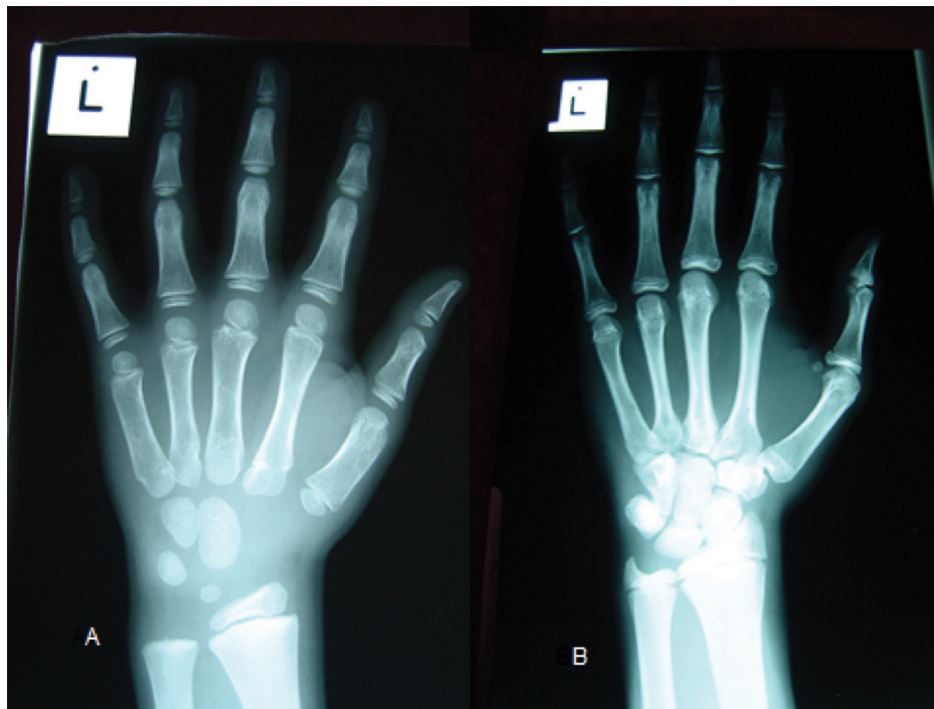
Two players with chronological birthdates within 1 week. Player A has a skeletal age of 6.3 years and player B 12.1 years, using the Fels method of X-ray assessment.
